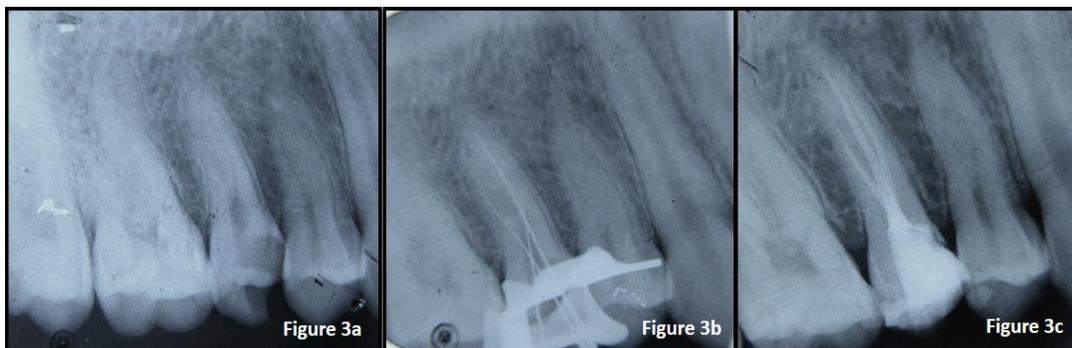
Preoperative Periapical Radiograph; Figure 3b: Working Length Radiograph; Figure 3c: Post Obturation Radiograph
